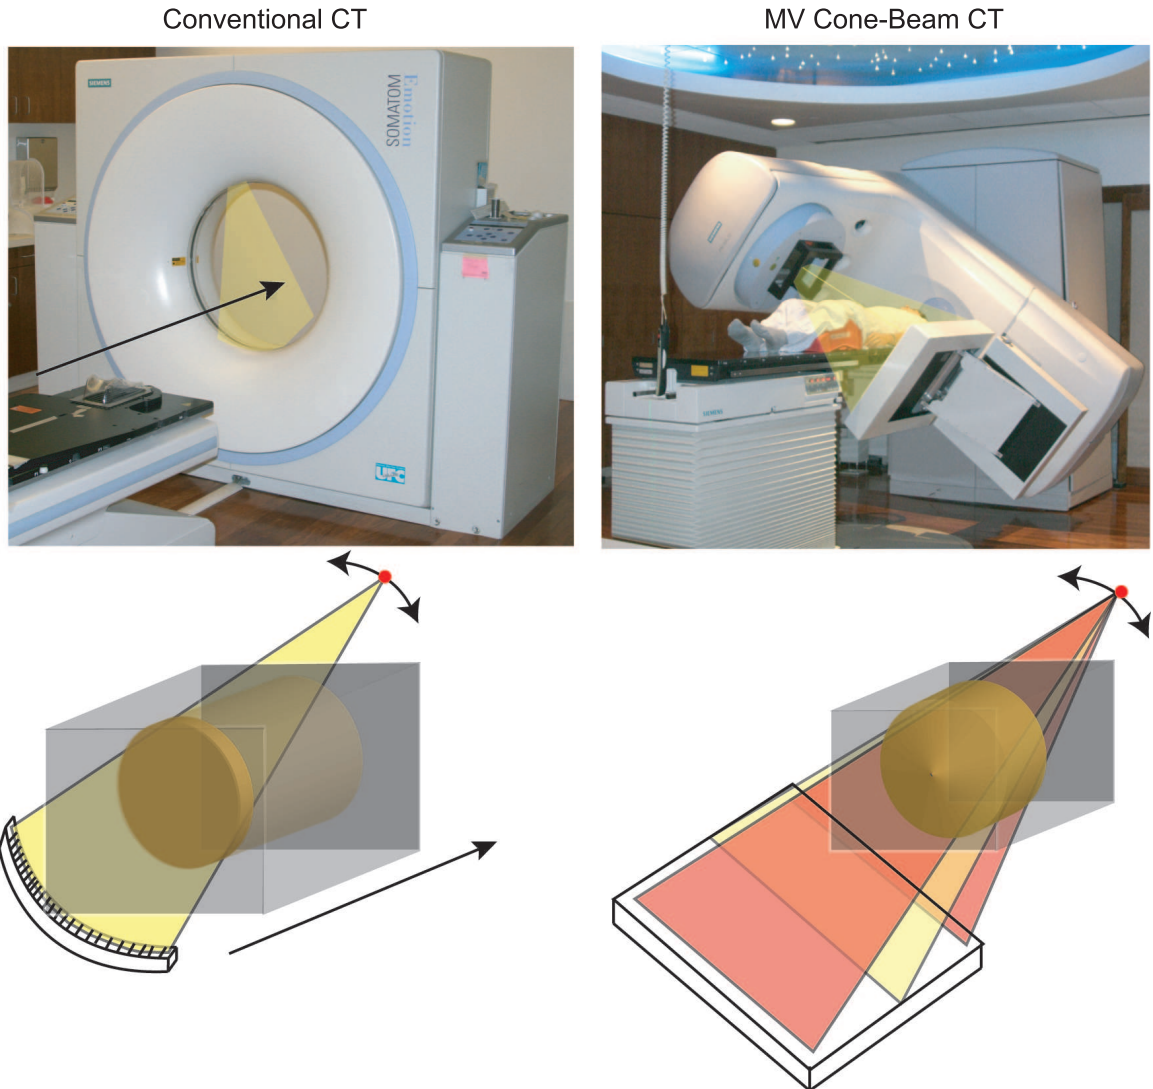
Basic principle of image acquisition and reconstruction volume for (*left*) conventional CT and (*right*) megavoltage cone-beam CT (MVCBCT). MVCBCT uses a 2-dimensional detector and a wide open radiation field to obtain an image over an extended region of the patient's anatomy without the need for table movement.
